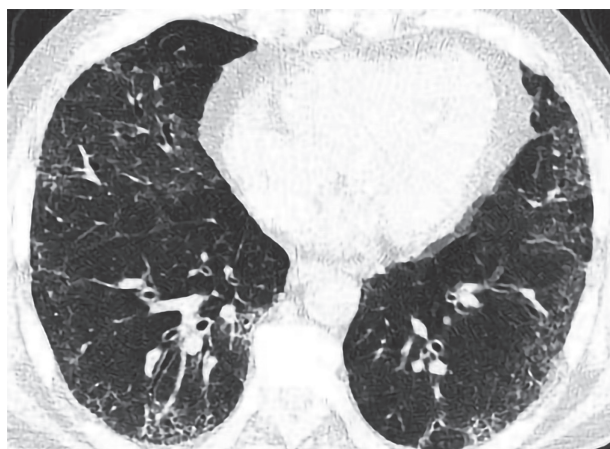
The post-treatment chest HRCT shows improvement in the lung's high-density areas, but there are still peripheral fine reticular shadows in both lungs, along with traction bronchiectasis.
